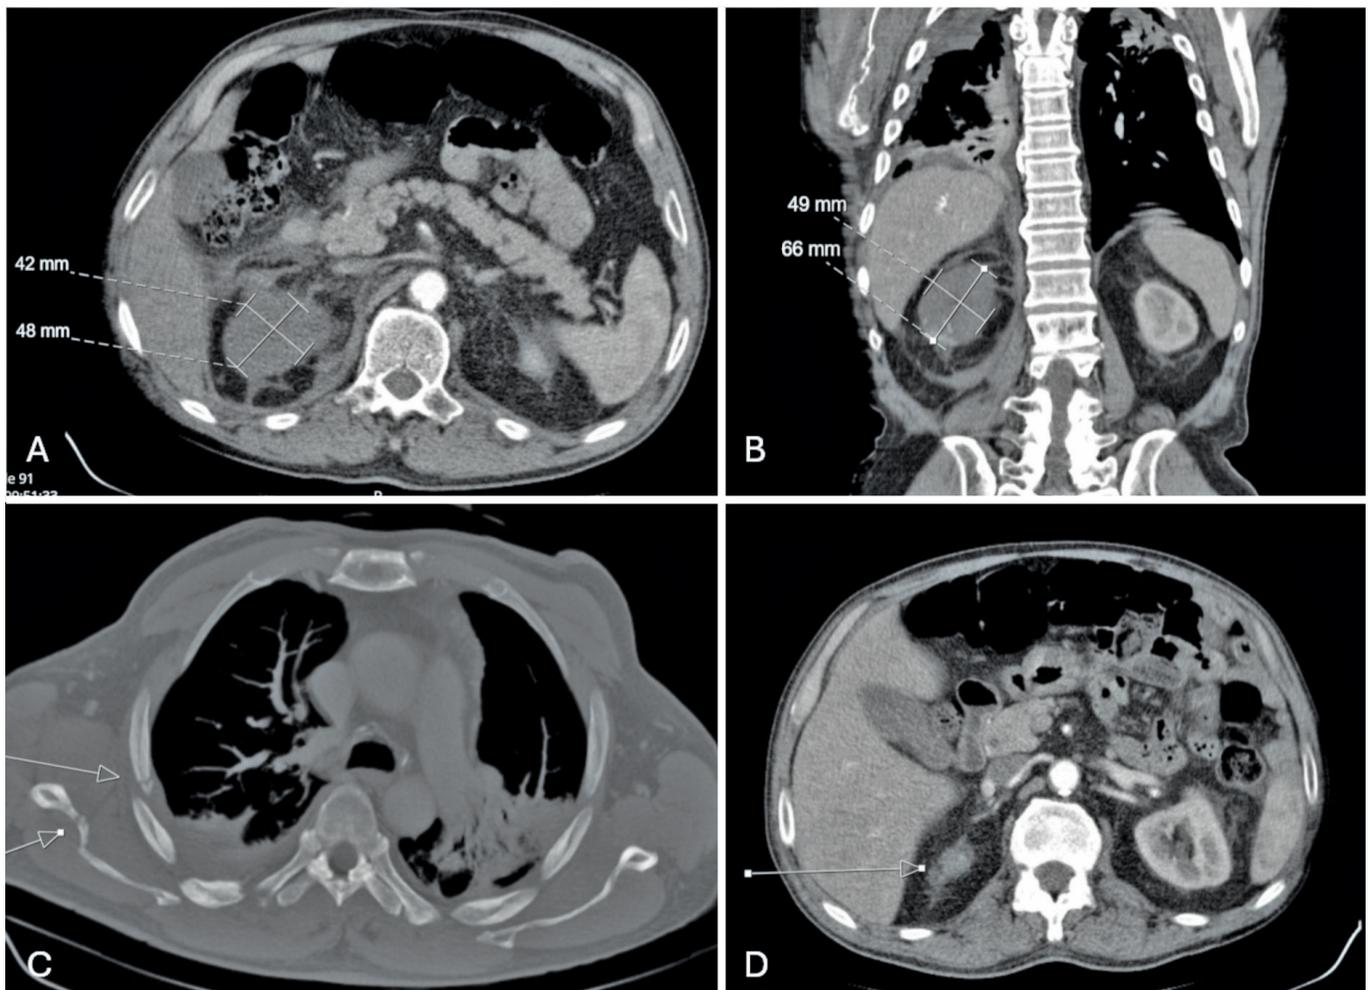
Case 1 – A. Axial CT showing globular hyperdense hematoma in the right adrenal gland; B. Coronal CT demonstrating extension of hemorrhage into the pararenal space and psoas; C. CT bone window highlighting associated right rib and scapular fractures; D. Axial follow-up CT showing resolution of the hematoma.
